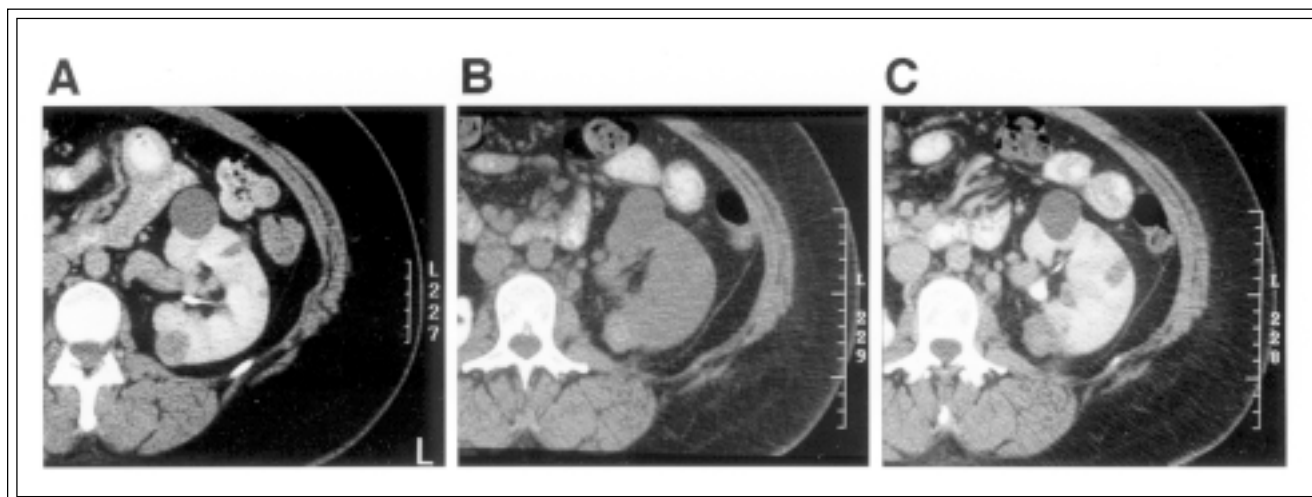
Posterior tumor. Panel A: Contrast CT prior to RFA demonstrated a solid tumor (2.7cm by 2.4 cm) with contrast enhancement of Δ HU+27. The solid nature of the tumor was confirmed by intra-operative ultrasound. The other lesions visible were cysts. Panel B: Two-month post-treatment non-contrast CT. A hyperdense treatment area (66 HU), presumably from tumor necrosis and hemorrhage is observed. Panel C: Contrast CT. The tumor was smaller (2.5 cm by 1.9 cm) and demonstrated no enhancement compared with the non-contrast image (66 HU \pm 65 HU; Δ HU-1).
